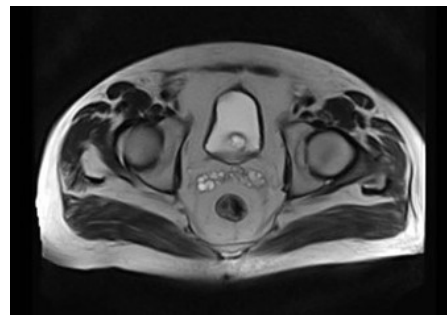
Pelvic magnetic resonance imaging showing a normal rectum without evidence of disease and no regional lymphadenopathy.
